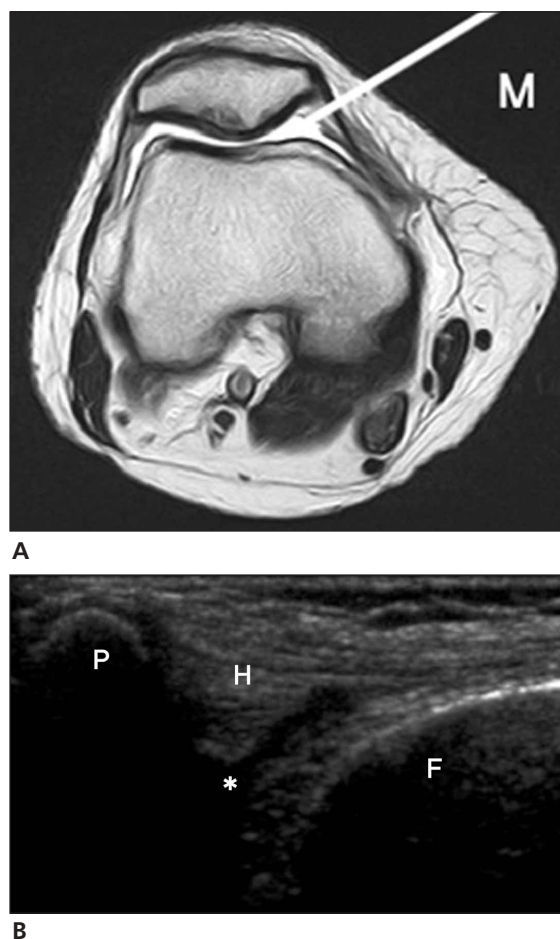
Axial T2-weighted MRI of the knee joint (A) and correlative transverse sonogram (B). Asterisk indicates the targeted area; F, femur; H, Hoffa fat pad; M, medial side; and P, patella.
